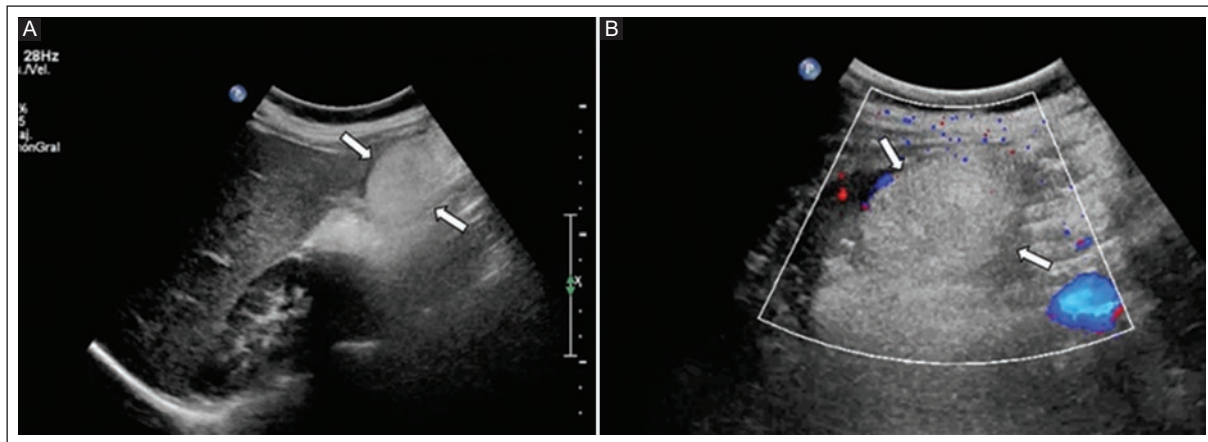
A: gray scale ultrasound shows a solid, ovoid, hyperechoic, non-compressible mass in the hepatorenal fossa with right-sided abdominal pain (white arrows). B: magnification of the hepatorenal fossa showing no blood flow with color Doppler ultrasound, suggestive of appendagitis (arrows).
